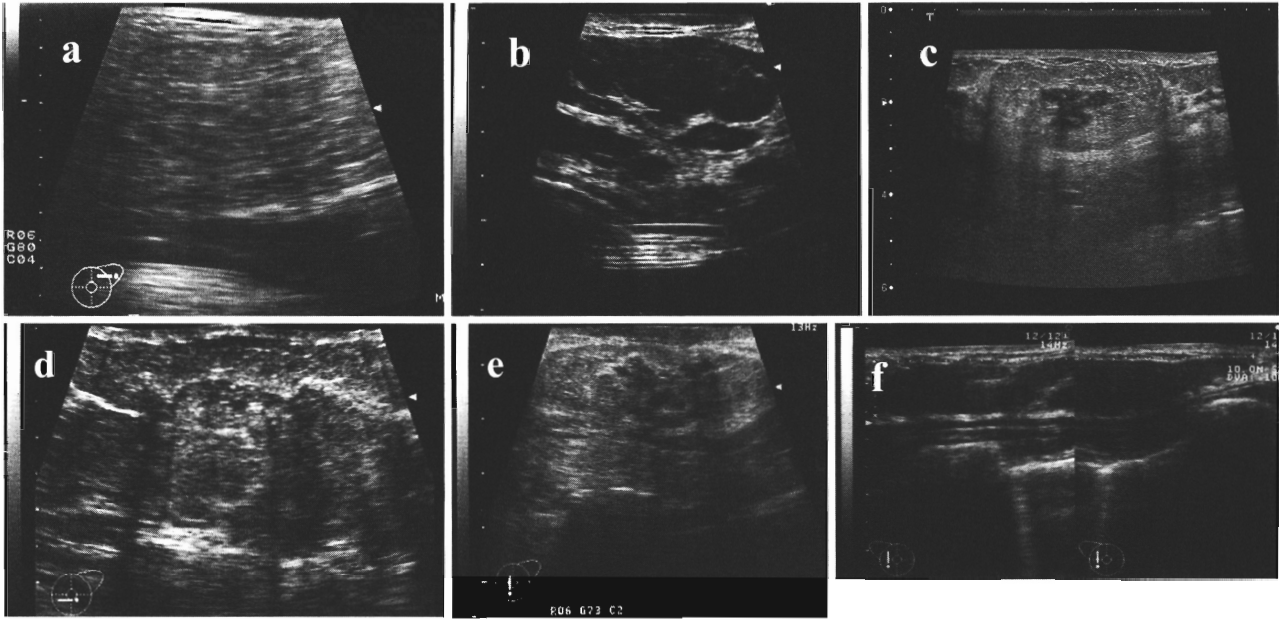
Mammary ultrasound findings
